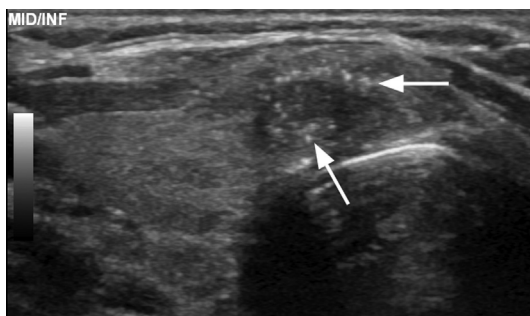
A 39-year-old woman with papillary thyroid carcinoma confirmed by FNA after transverse gray-scale ultrasound demonstrated a hypoechoic nodule with multiple PEF (*arrows*).
